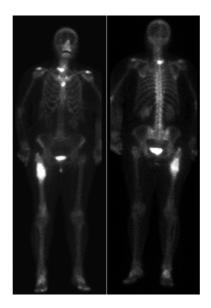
Bone scintigraphy obtained after intravenous injection of <sup>99m</sup>Tc-MDP in a 61-year old patient with newly diagnosed breast cancer in whom the scan was performed for preoperative staging. There are multiple areas of markedly increased uptake corresponding to previously unknown, asymptomatic metastatic lesions in the cervical spine, in the sternum, and in the upper third of the right femur. Such metastatic diffusion disqualifies the patient from curative surgery of the primary tumour.
